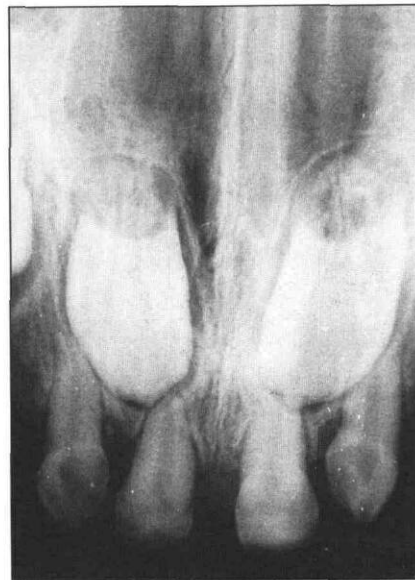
Periapical radiograph of the premaxilla of Case 2. Notice the missing permanent lateral incisors and the dens invaginatus in both teeth.
